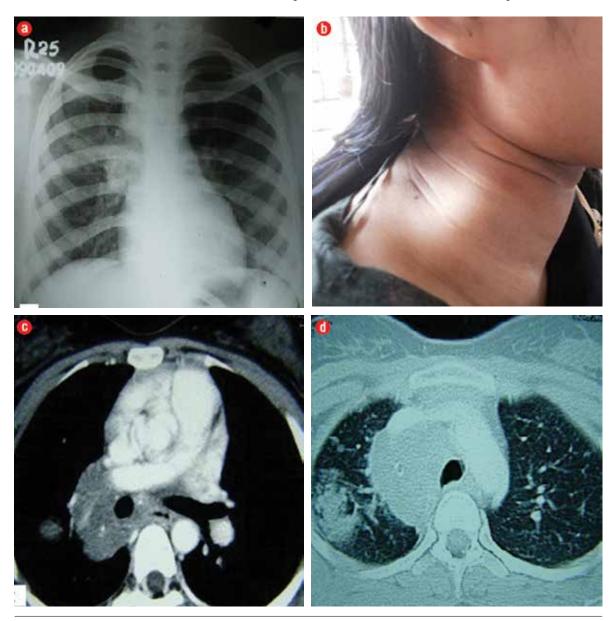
Clinical and radiological findings during initial presentation. (a) Chest X-ray posteroanterior view showed right paratracheal and hilar shadow. (b) Diffuse swelling of the right side of the neck. (c) Contrastenhanced computed tomography (CT) of the thorax (mediastinal window) showing non-enhancing mass lesion in mediastinum with few calcified foci encircling the right main bronchus. (d) Contrast-enhanced thorax CT (lung window) showing parenchymal non-homogenous opacity involving the right upper lobe.
